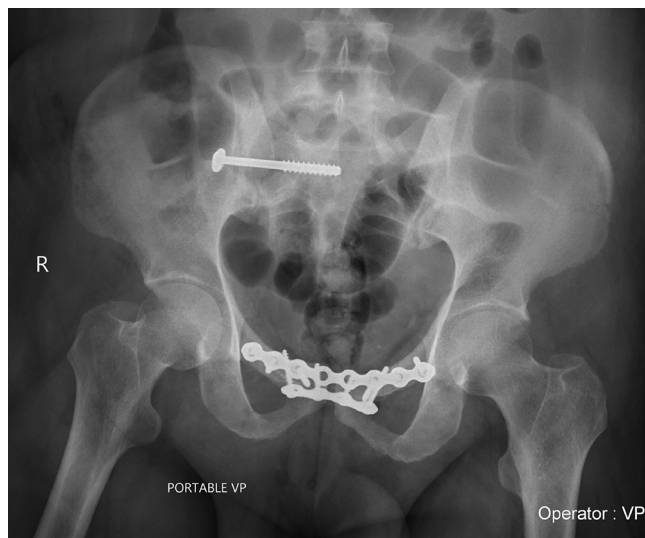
Immediate postoperative radiograph showing good reduction.
